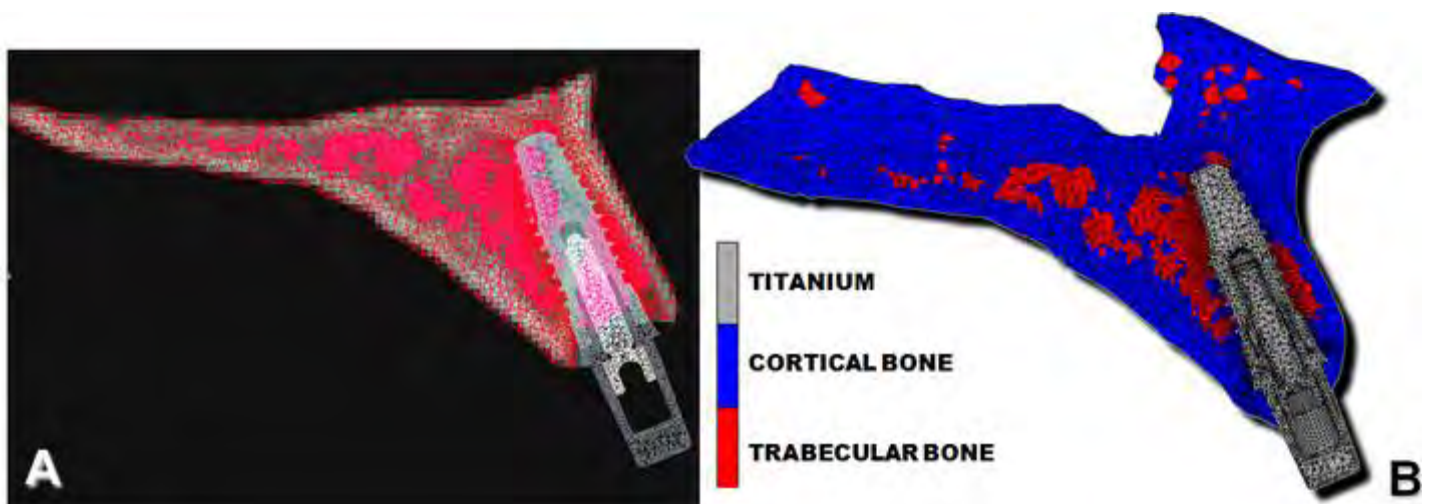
Assignment of CT based properties to the bone: buccopalatal medial plane view. A – Bone and implant system solid meshes superposed to the CT image. B – 3D FE model with the assigned material properties. Note the coincidence between the grey values in CT scan (A) and the elements assigned as cortical bone (B). Also note that the CT is a 2D slice, while the 3D FE model is shown as a sectional view starting in the plane of the CT slice and showing also the bone behind this plane.
